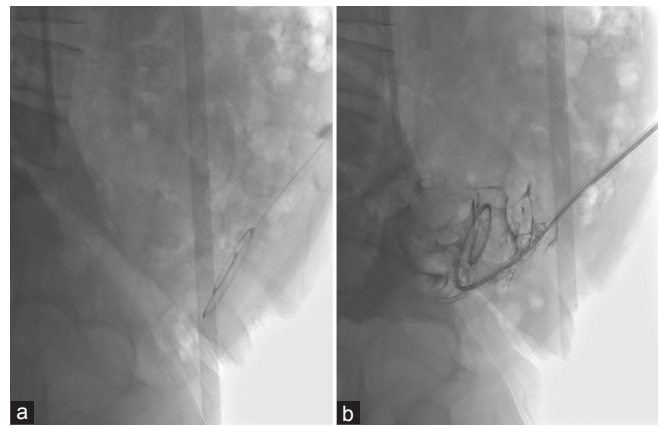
(a) Lateral pelvic radiograph showing malpositioned catheter into the anterior abdominal cavity, which resulted in poor outflow. (b) Postwire manipulation with stiff glide to reposition the tip into the pelvis
